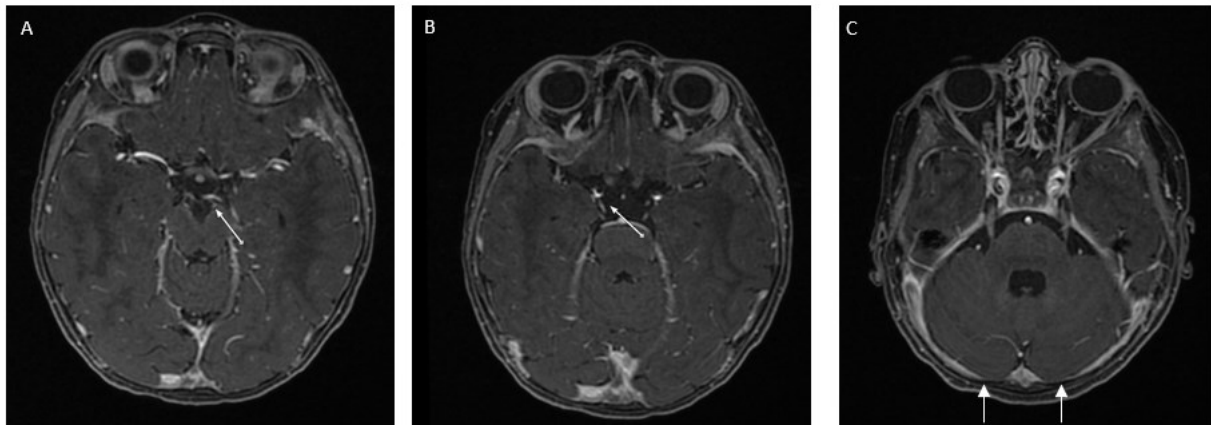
Brain MRI with contrast, FLAIR sequence. Brain MRI at age of 18 months revealed abnormal enhancement involving the bilateral oculomotor (A, B) as well as the trigeminal cranial nerves (C).
